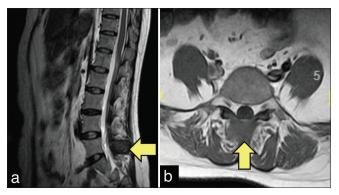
MRI lumbosacral without contrast with (a) sagittal L5 , yellow arrow showed hypodense lesion (b) axial L5 view showed a hypodense lesion (yellow arrow).
